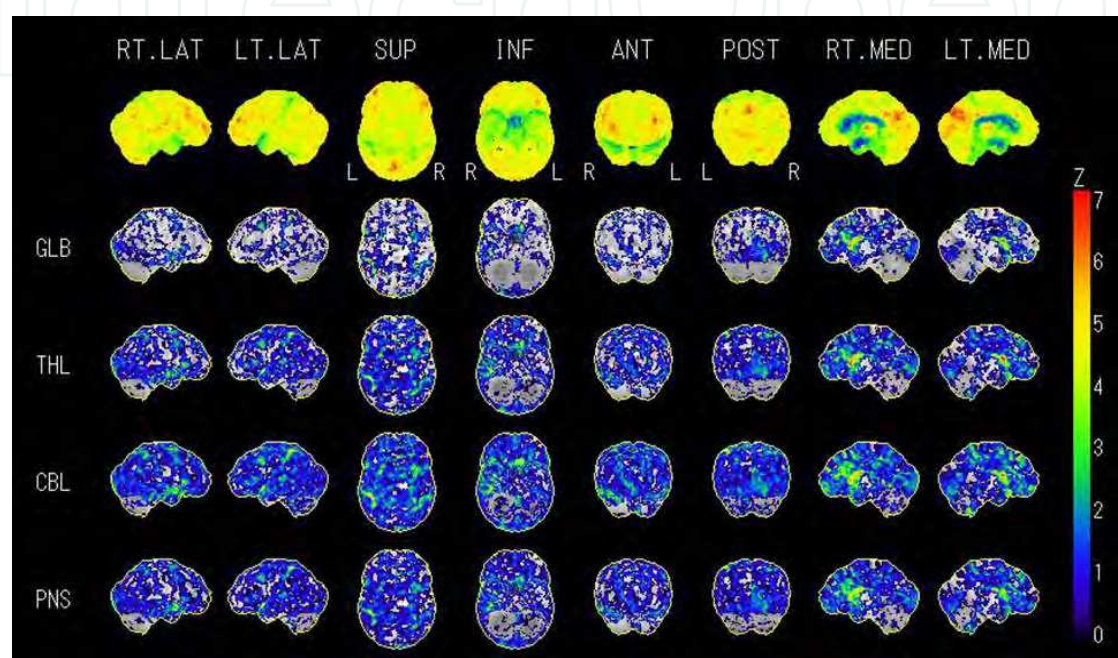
FDG-PET study of Huntington disease. Hypometabolism is clearly recognized in the caudate and putamen by 3D-SSP.
